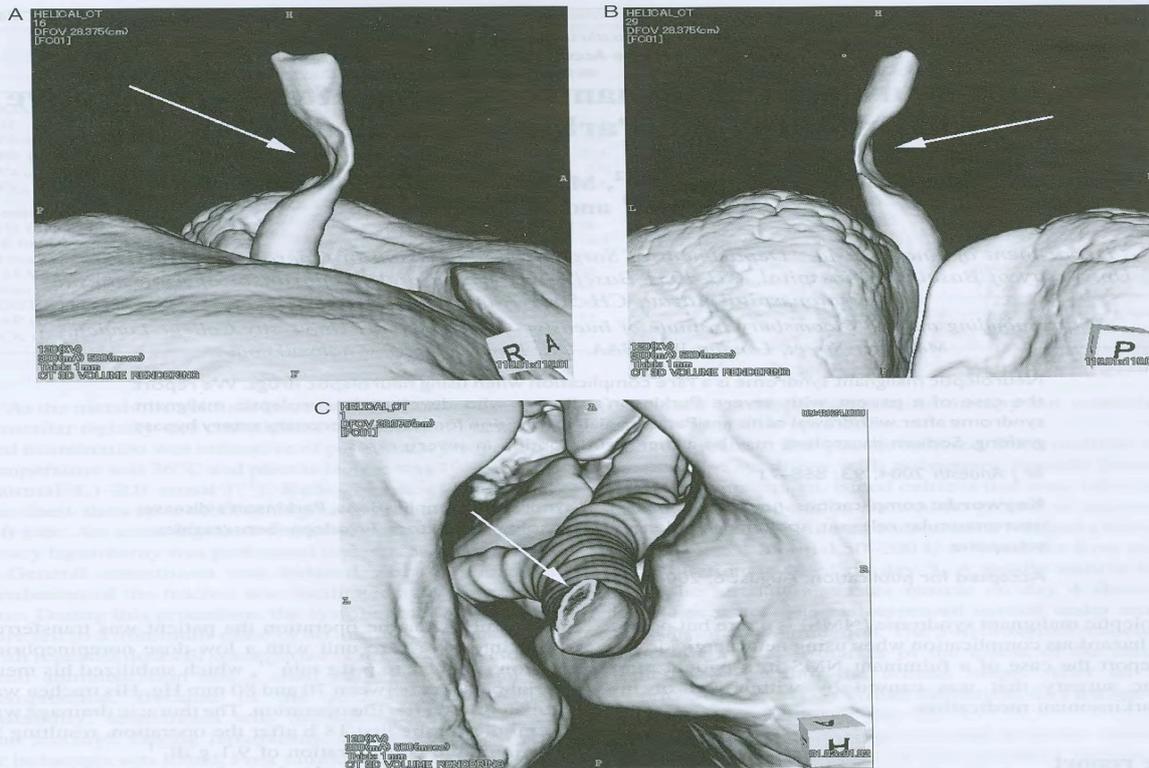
3D images of the trachea obtained from multi-slice CT. Diagonal right frontal view (A), rear view (B). Image (C) has been reconstructed downwards from the region of maximal narrowing. Arrows indicate the narrowest region of the trachea.
